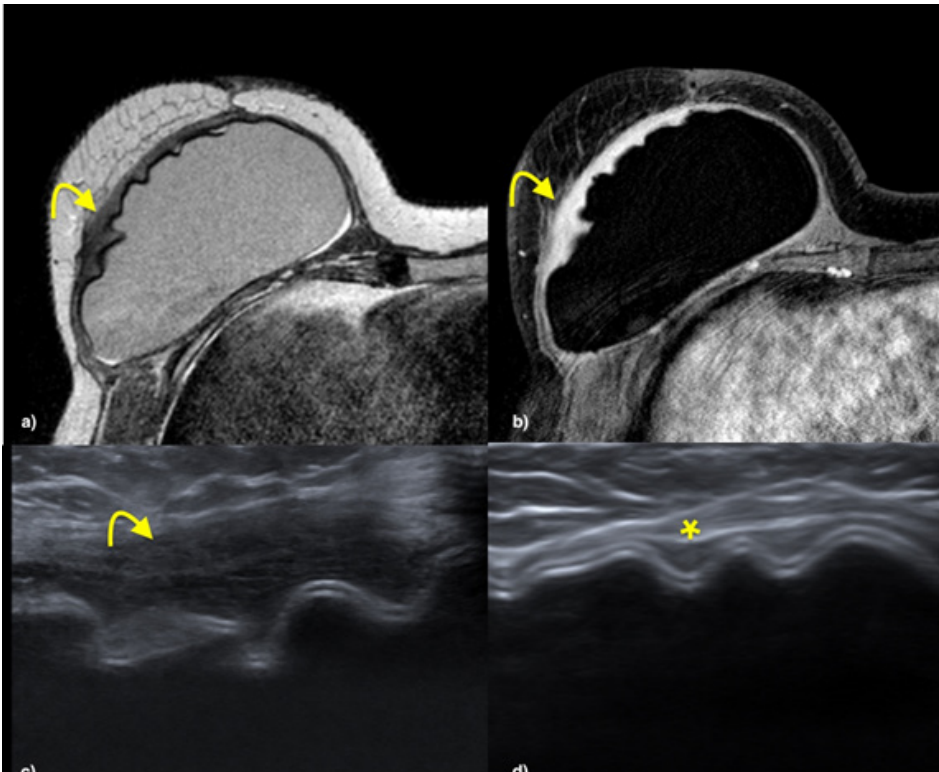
A 42-year-old female with a history of breast carcinoma on the right with breast reconstruction with a *Latissimus dorsi* flap and implant. The MRI study demonstrated marked thickening of the muscle flap (a), with diffuse enhancement after administration of contrast (b) in relation to the local inflammatory process. The complementary ultrasound study (c) was concurrent, and a favorable clinical course was observed after antibiotic therapy and anti-inflammatory therapy, with disappearance of these findings in the ultrasound of control at 3 months (d).
